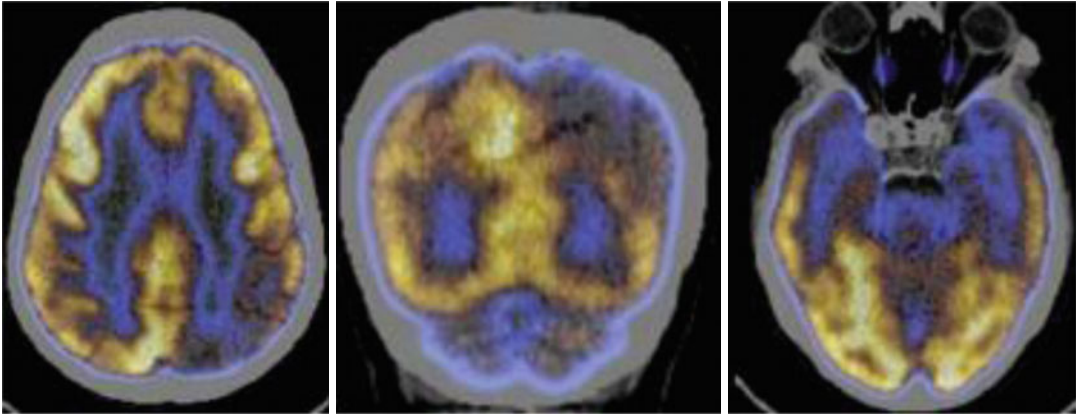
Transaxial fused ^{18}F -FDG PET-CT image of a case of amnesic MCI, MMSE=26, showing left parietal (*left*), precuneus (*middle*), and temporal (*right*) hypometabolism suggesting high likelihood for progression to AD
